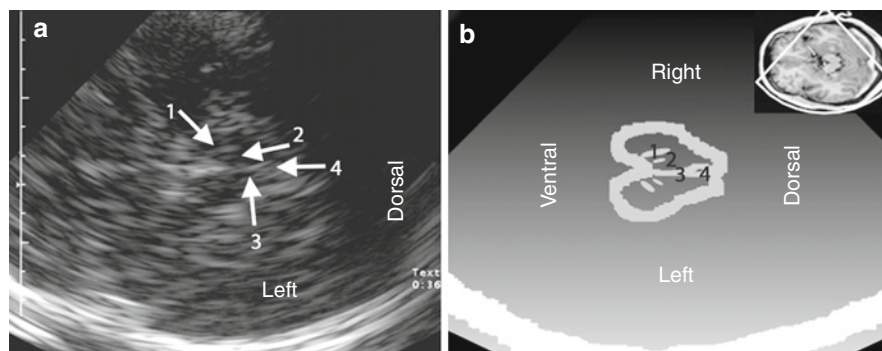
Sonogram of the brain. (a) Axial section at midbrain level. The contralateral cranial bone is readily identified as a bright structure at the lower edge of the image. At the center, the mesencephalon is viewed as a butterfly-shaped hypoechoic structure surrounded by the strongly echogenic basal cisterns. Visualized at increased echogenicity in the midbrain cross section is the substantia nigra bilaterally
